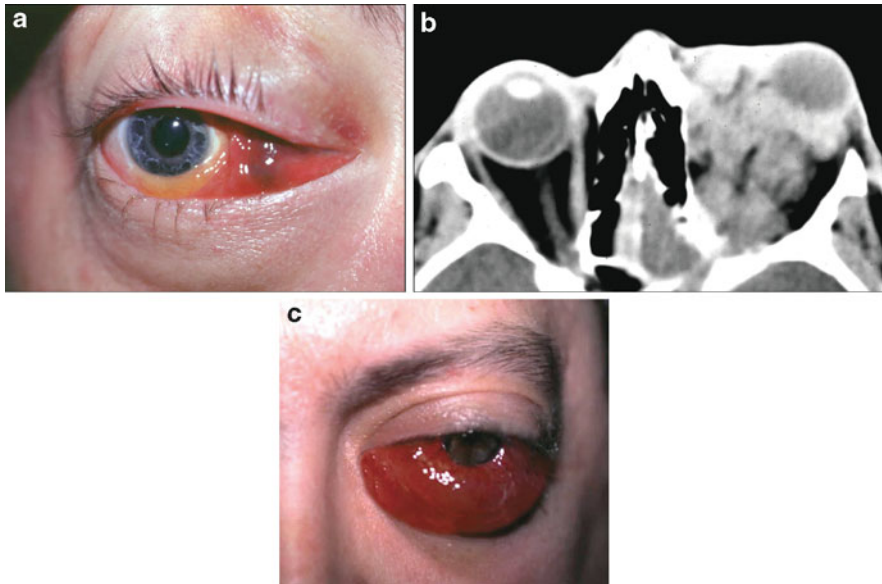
(a) Orbital lymphangioma with proptosis and hemorrhagic chemosis. (b) CT scan of orbital lymphangioma diffusely infiltrating orbital tissues. (c) Massive, acute proptosis and chemosis after acute hemorrhage associated with lymphangioma
